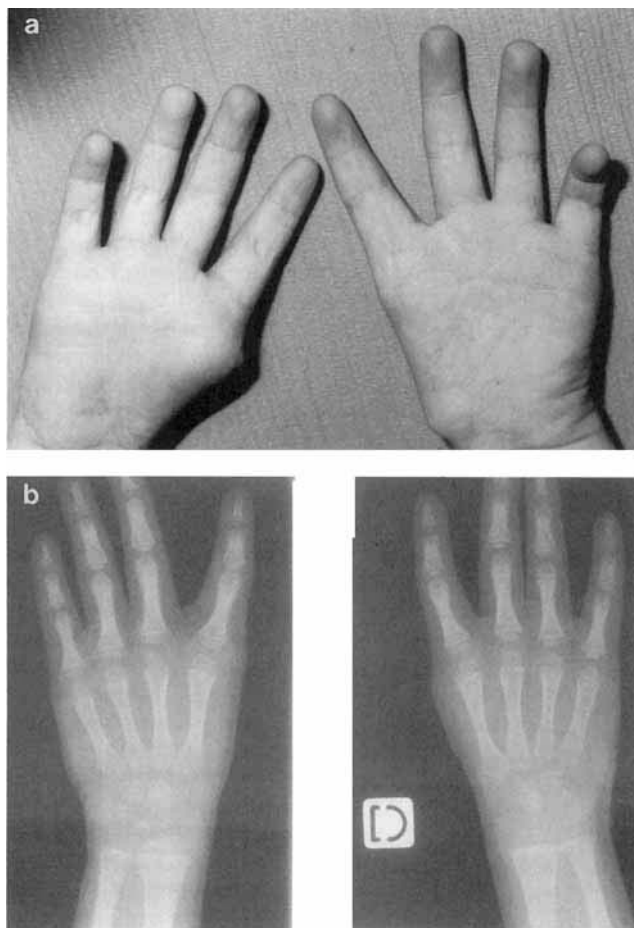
Post-surgical appearance of the hands (a) and corresponding radiography (b).
